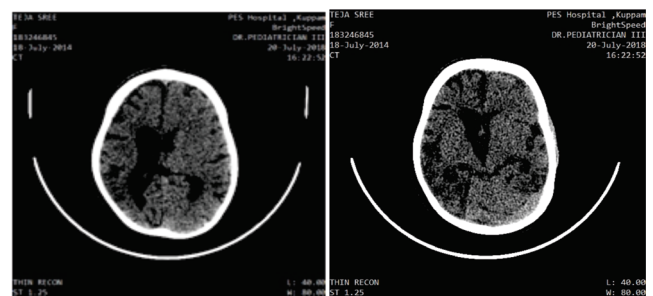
Cranial CT showing right cerebral atrophy with ipsilateral ventriculomegaly, contralateral cerebral hypertrophy
